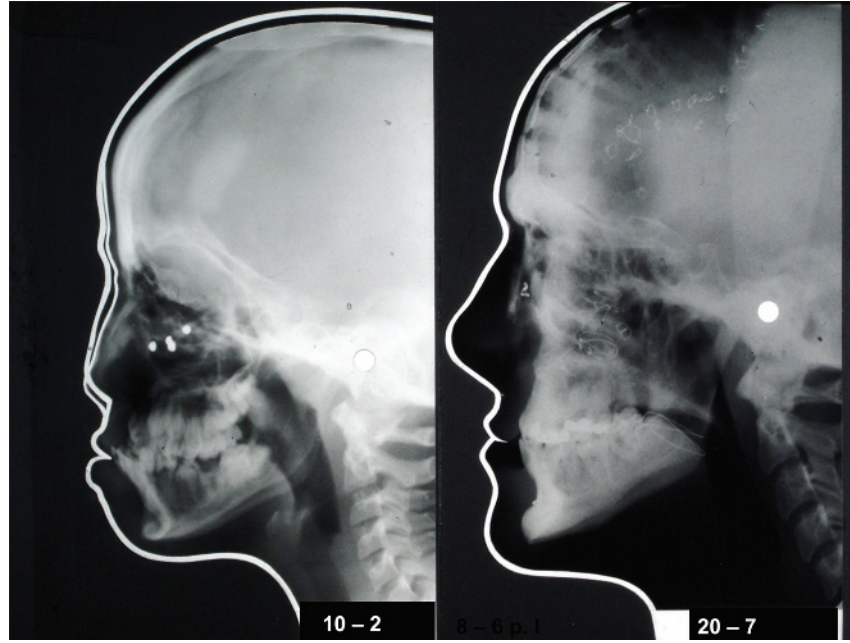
Presurgical and final lateral cephalometric radiograph of the skull.
